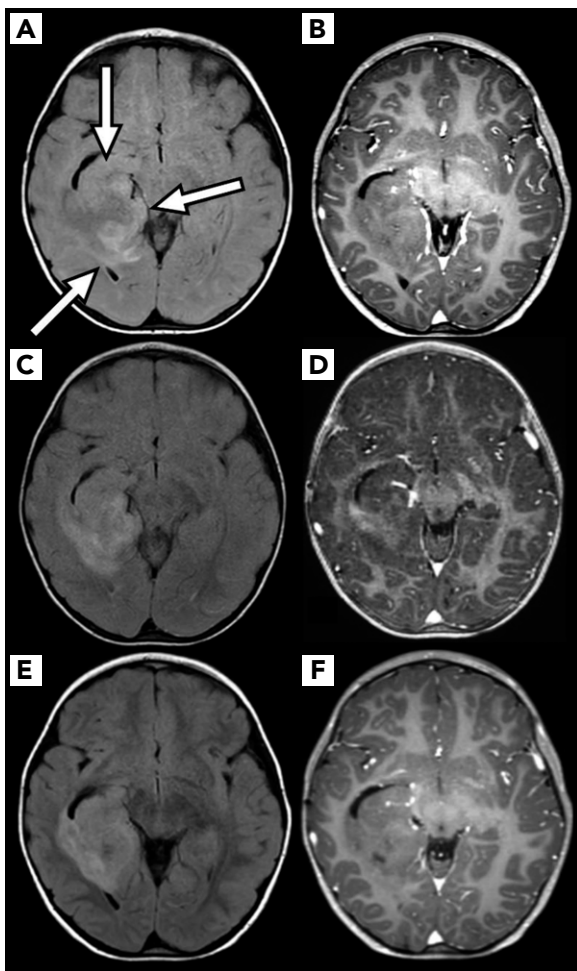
(A) Axial FLAIR and (B) postcontrast enhanced T1-weighted MRI show a large FLAIR hyperintense intra-axial mass involving the right medial and posterior temporal lobe (arrows). There were few small foci of postcontrast enhancement within this mass. Serial MRIs obtained at (C, D) 4 months and at (E, F) 2 years 9 months after starting treatment with larotrectinib show relative stability of this mass. There was interval improvement in the few contrast-enhancing foci seen on the initial scan. Abbreviation: FLAIR, fluid attenuated inversion recovery.
